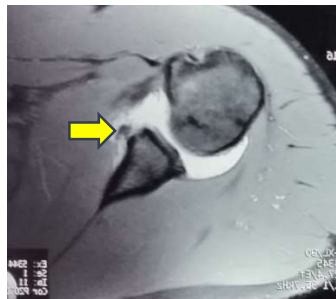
MRI of Labral tear
